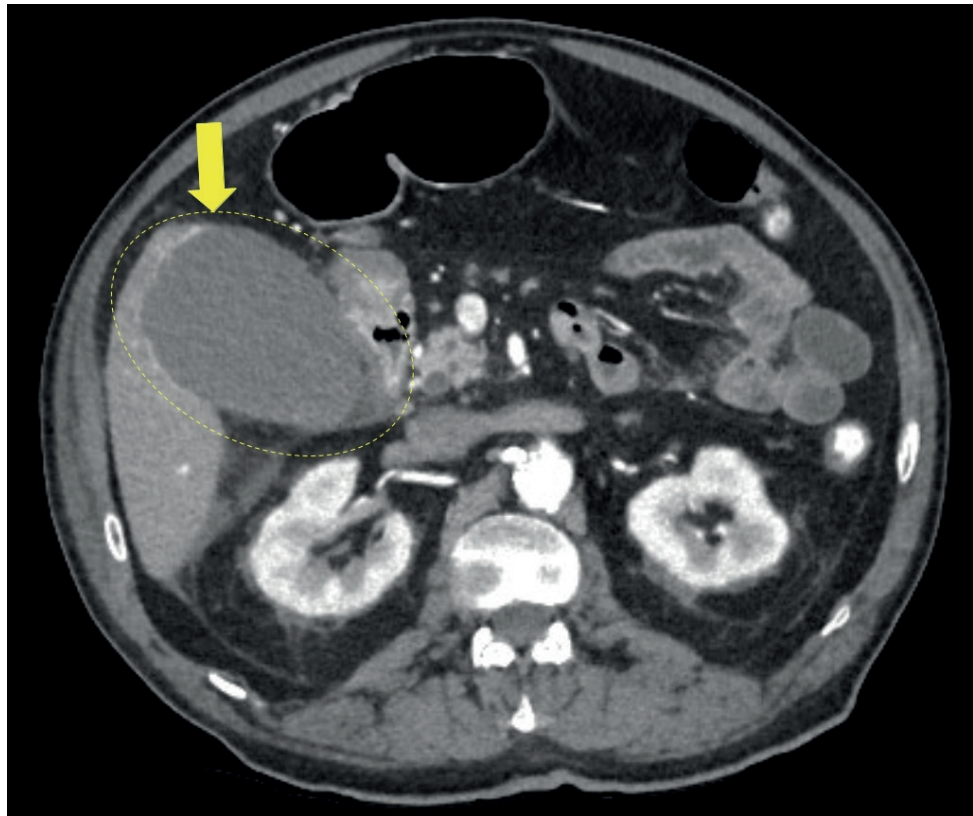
Axial section from the contrast-enhanced abdominal computed tomography scan, showing a distended gallbladder with wall enhancement (arrow) suggestive of advanced acute cholecystitis
